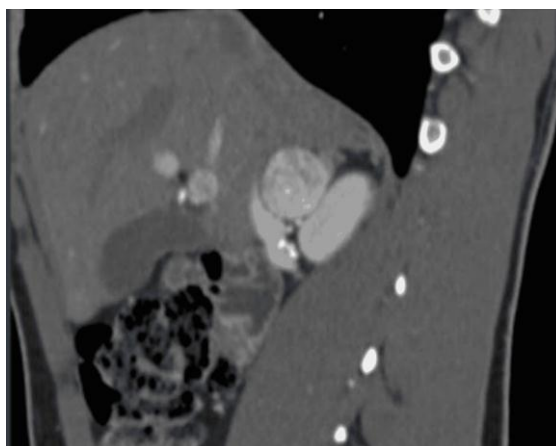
Abdominal CT scan, sagittal section with contrast agent injection in arterial phase, passing through the right adrenal gland.
